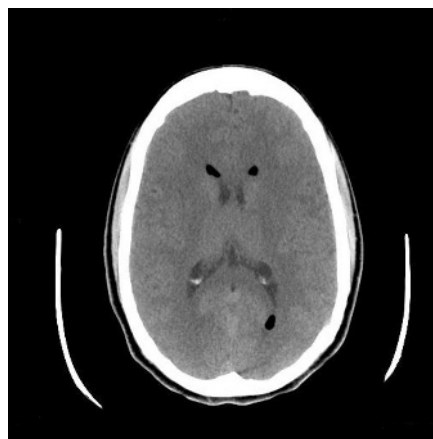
CT scan of the head in case 2.
